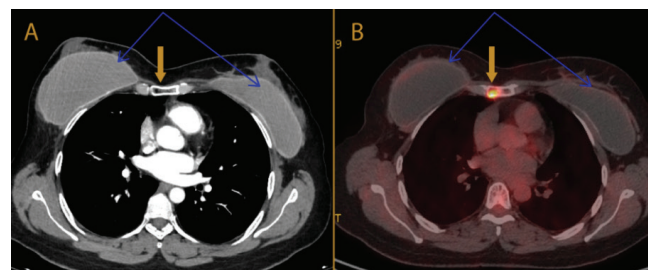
Thoracic CT (A) and PET/CT (B) showing a lytic lesion in the sternal body (yellow arrow) and bilateral breast implants (blue arrow).
